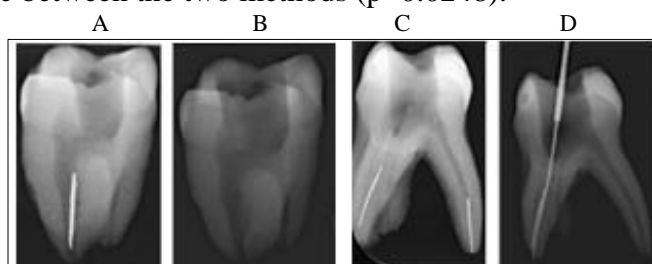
X-ray imaging before and after treatment; A) B) Ultrasonic method; C) D) Bypass technique
